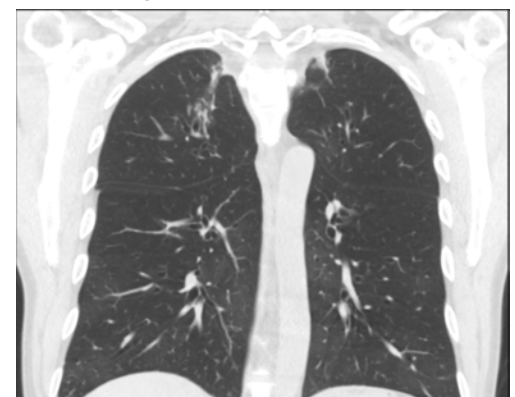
Coronal view CT
